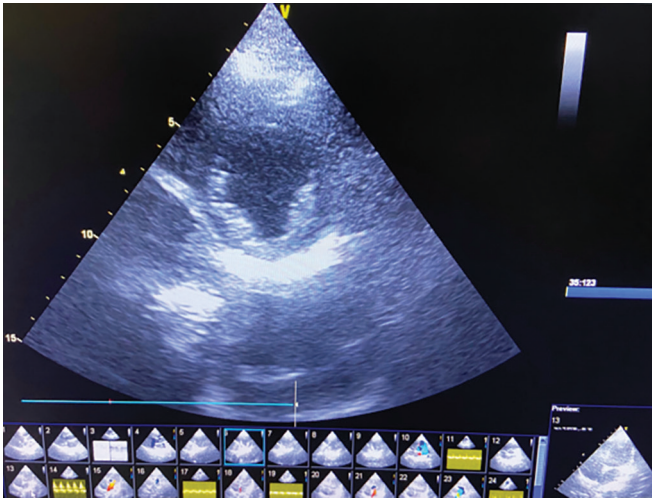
Antenatal echocardiography showing global sluggishness and hypokinesia of the left ventricle
